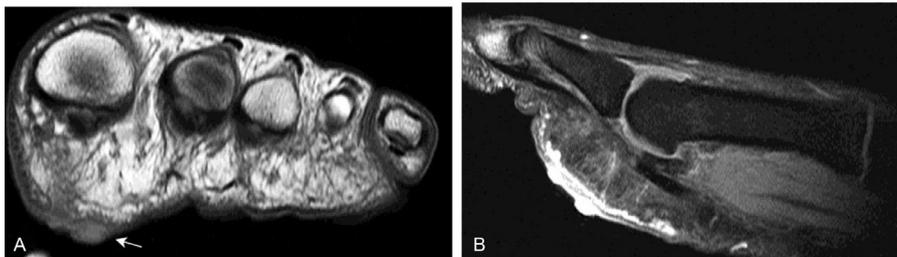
Melanoma. (A) Coronal short-axis T1WI shows nodular superficial masses in the sole of the foot that are slightly hyperintense than the muscle (white arrow). (B) Sagittal postcontrast fat saturated T1WI shows intense contrast enhancement along the skin and the masses. T1WI, T1-weighted images.
